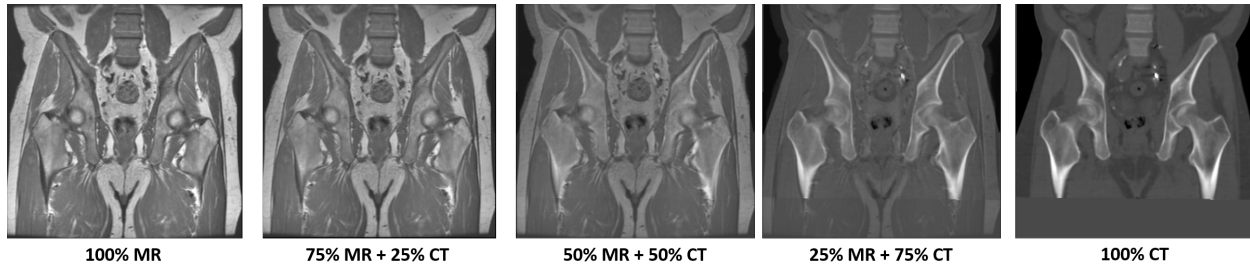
Visualization of ANTs registration result in 3D Slicer through MR/CT volume blending
